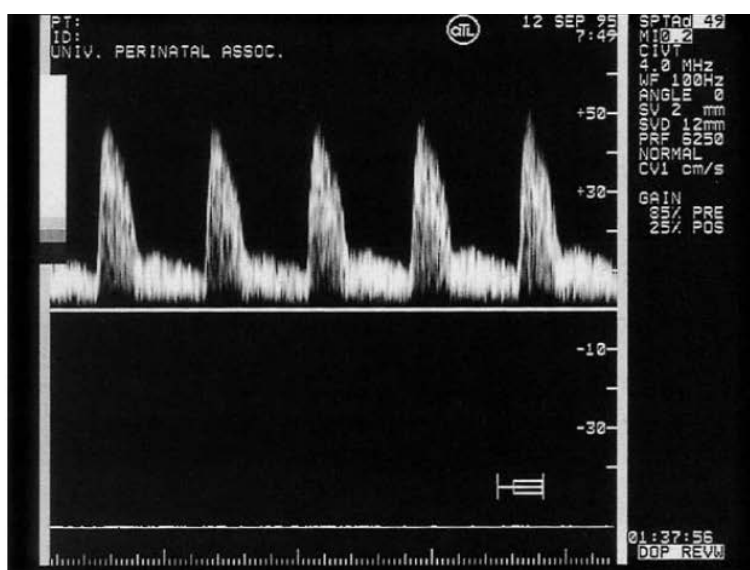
Typical pulsed wave Doppler waveform of the uterine artery during luteal phase of a normal menstrual cycle
